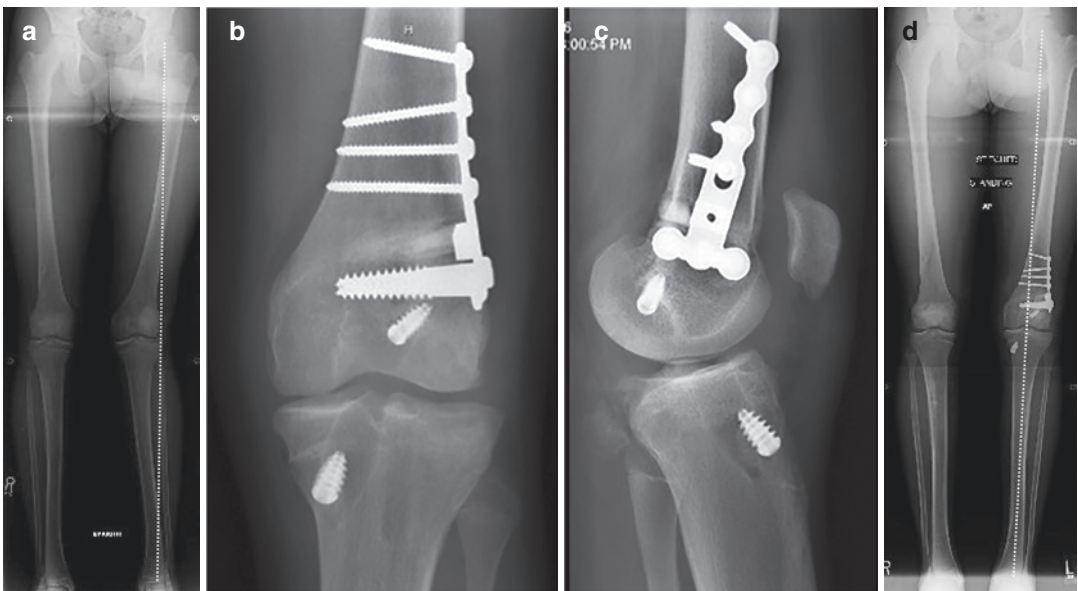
A 17-year-old male who underwent ACL “repair” several years prior with pain and recurrent instability. (a) Full-length x-ray showing mechanical axis indicative of significant genu valgum (dashed white line). (b) AP x-ray following DFO and ACL reconstruction. (c)
